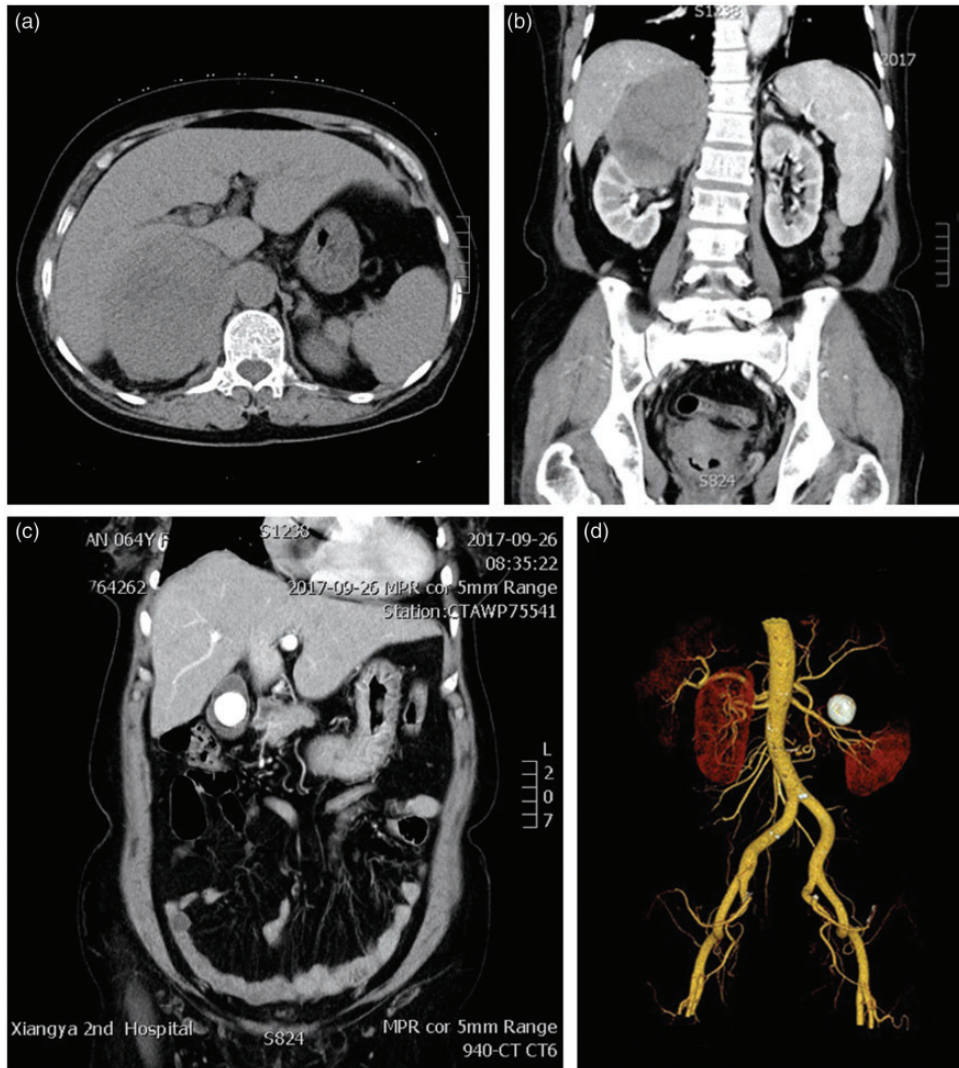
Abdominal computed tomography scan. (a) Transverse section. (b) Coronal section. (c) Three-dimensional reconstruction. (d) Gallbladder stone.
